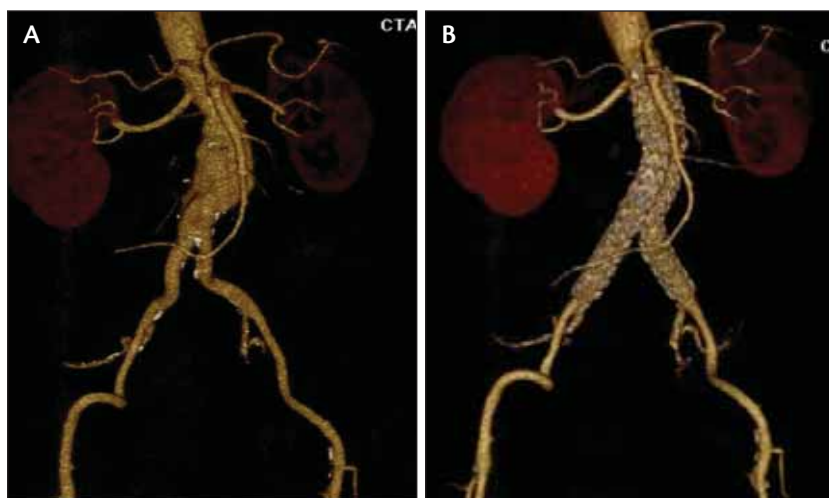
Preoperative planning 3D CTA (A) and subsequent 2-year postimplantation 3D CTA (B) showing accurate position and function of an Endurant Stent Graft (Medtronic, Inc., Minneapolis, MN). Note precise landing of the ends of the device at the renal and distal iliac levels.
